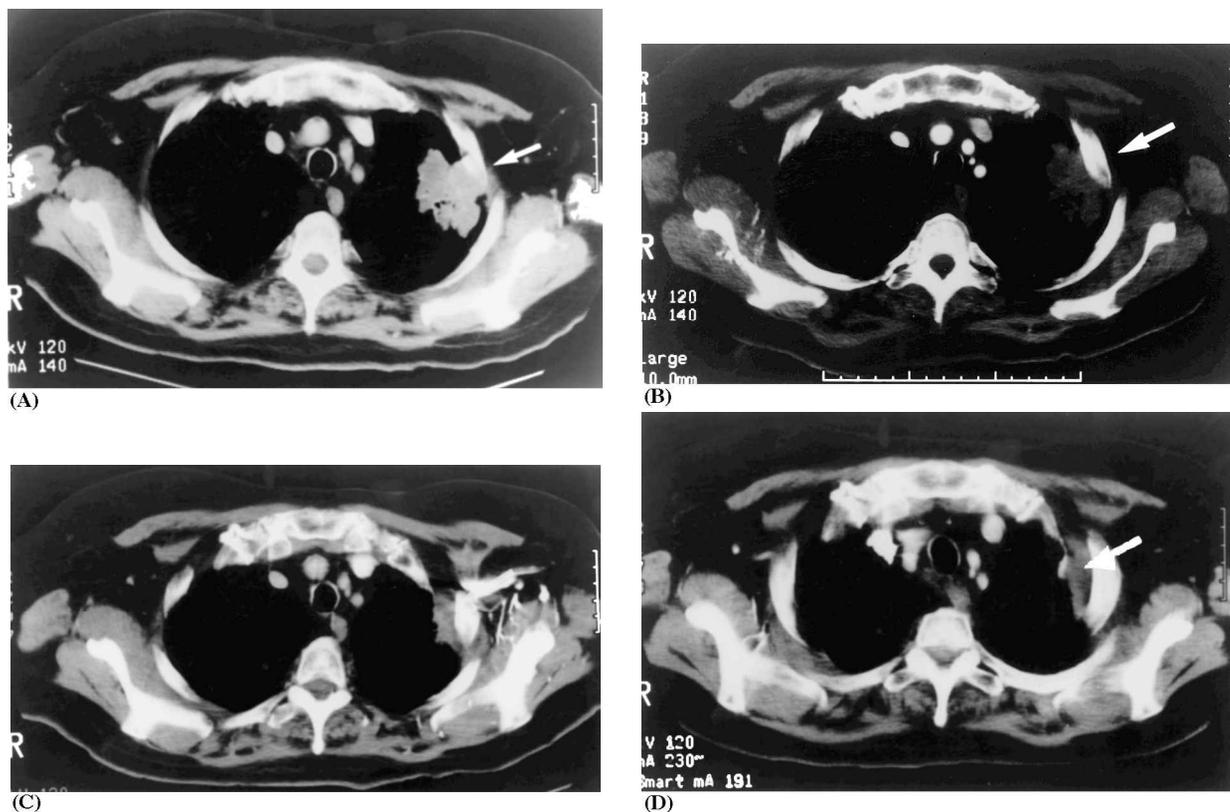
Computed tomography (CT) scans of patient K following six courses of 10^9 plaque-forming units of Ad-*p53*, an adenovirus vector carrying the wild-type *p53* complementary DNA. A) Before treatment, arrow shows recurrent left upper lobe adenocarcinoma, which progressed after 66 Gy of external beam radiation therapy and six courses of paclitaxel and carboplatin (CT scan volume: $3 \times 4 \times 5$ cm = 60 cm³). B) At one month after treatment, arrow shows tumor regression after one course of Ad-*p53* treatment (CT scan volume: $2 \times 3 \times 5$ cm = 30 cm³). C) At 8 months after treatment, image shows tumor regression following six courses of Ad-*p53* gene therapy (CT scan volume: $2 \times 2 \times 3$ cm = 12 cm³). D) Stable tumor 18 months after beginning treatment with Ad-*p53* (CT scan volume: $2 \times 2 \times 3$ cm = 12 cm³). No viable tumor was demonstrated during the last 4 months of therapy (14 sequential percutaneous biopsies), and the patient was observed off all treatment for 12 months without evidence of tumor progression.
